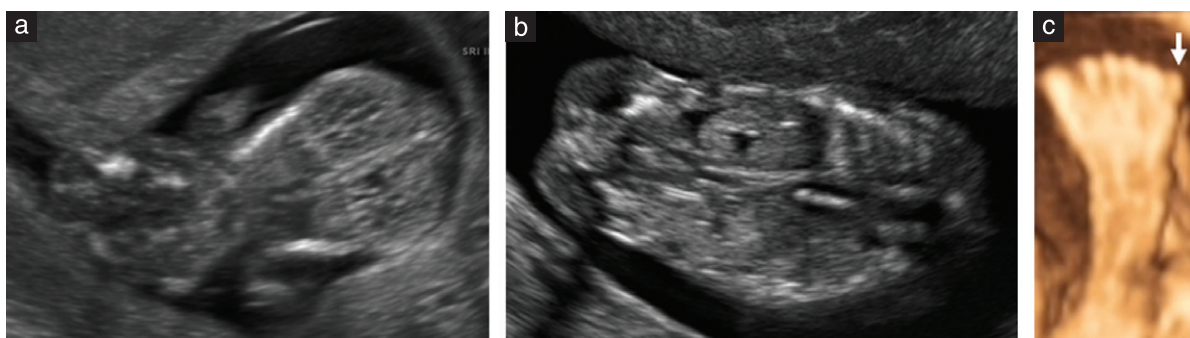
Axial transvaginal ultrasound images of fetal head showing a cranial cephalocele at 13 + 4 weeks (a) and an encephalocele at 12 + 6 weeks (b). Note enlarged cisterna magna, enlarged third ventricle and absent brain tissue within the defect in (a). Arrow depicts brain tissue within the defect in (b).
